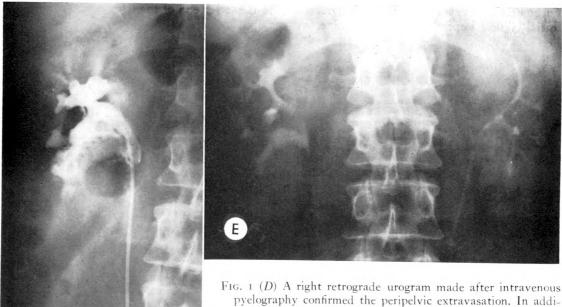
Case 1. (A) Scout roentgenogram prior to injection for intravenous pyelography. Note well delineated right psoas border. (B) Sixty minute pyelogram showing obliteration of upper one-third of right psoas border and peripelvic extravasation of contrast material. (C) Two hour pyelogram. Note complete obliteration of the psoas border and dissection of urine and contrast material along psoas border. Note "white stripe" just above the right iliac bone produced by the extravasated contrast material dissecting in the retroperitoneal tissues.
